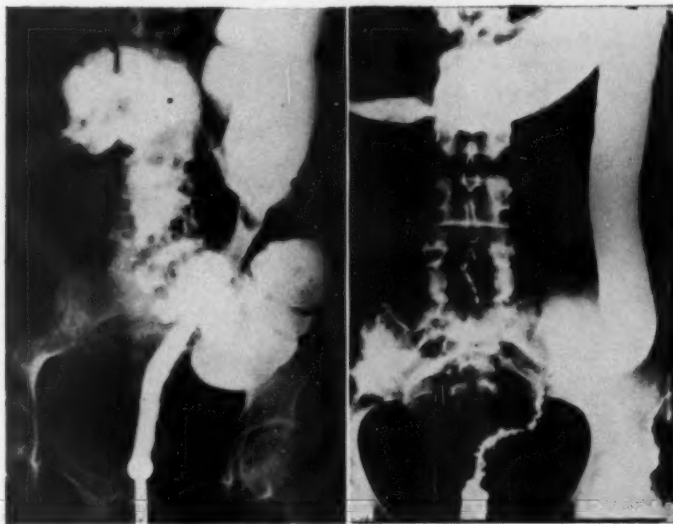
(left). X-ray showing tubular stricture of rectum, sigmoid and descending colon. The colon is contracted and the rectosigmoid angle obliterated.
